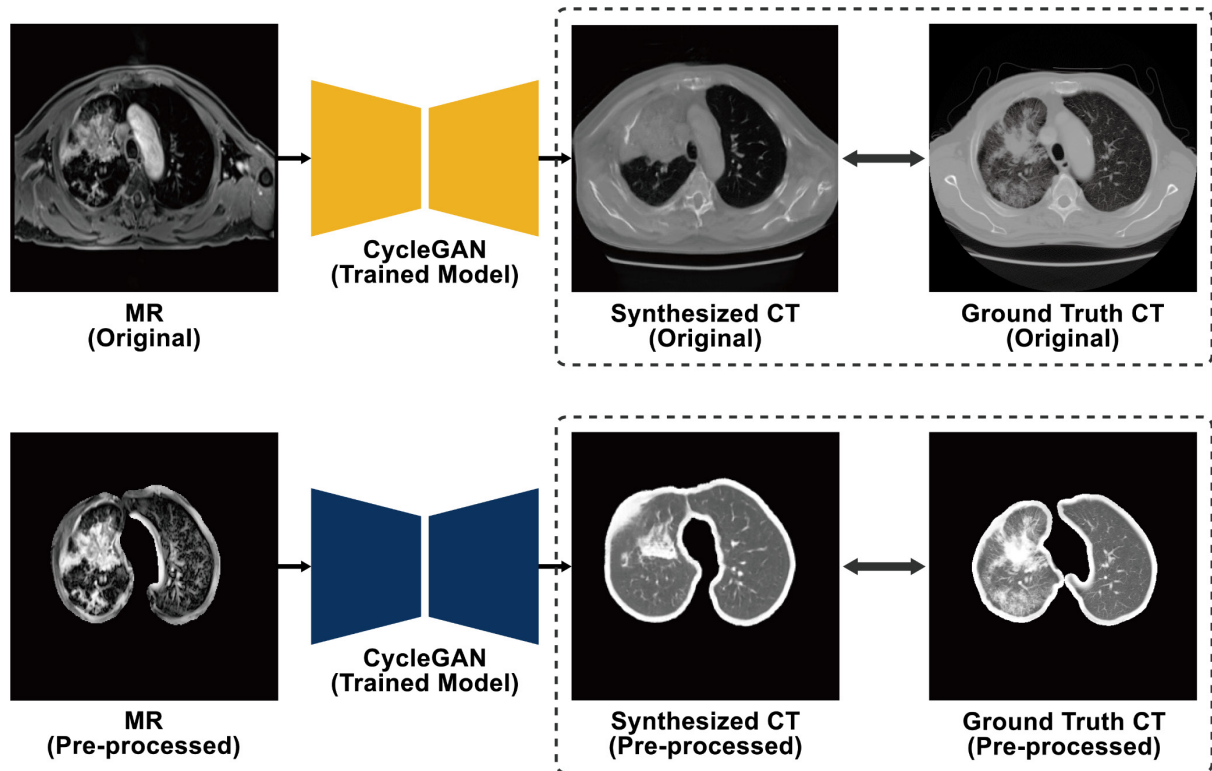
Pseudo CT image synthesized from the original MR and pre-processed MR.
